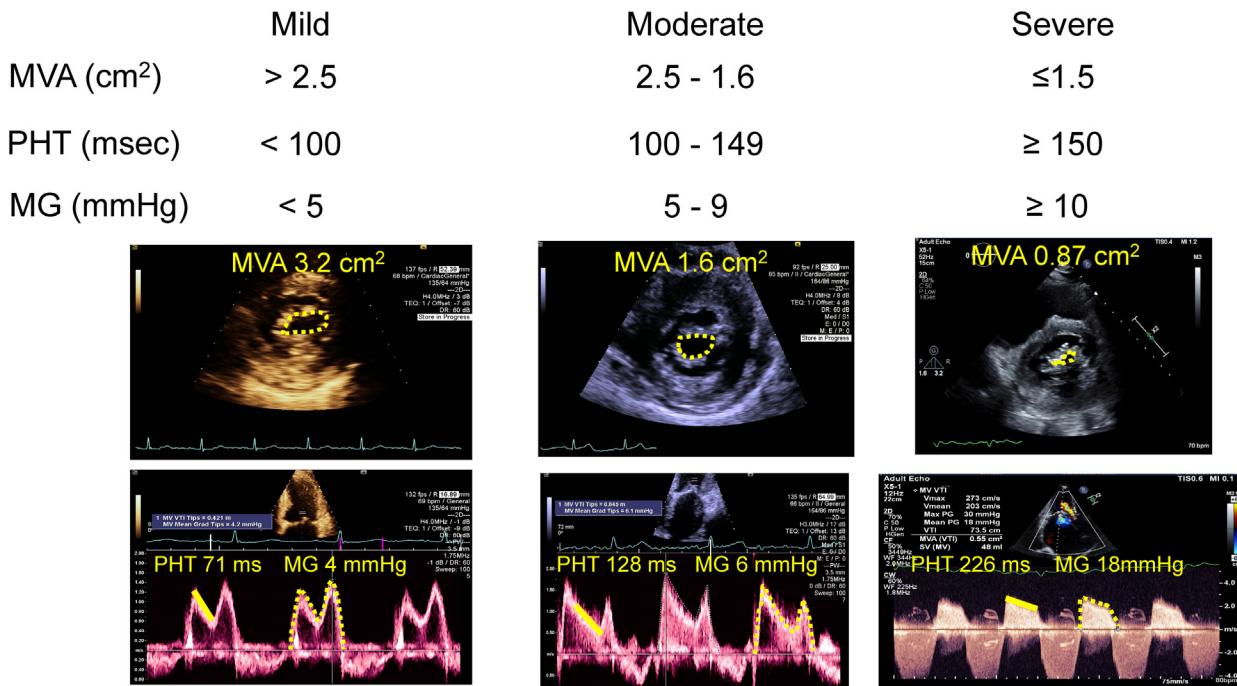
Stages of mitral stenosis by echocardiographic parameters. MVA, Mitral valve area; PHT, pressure half-time; MG, mean gradient.
